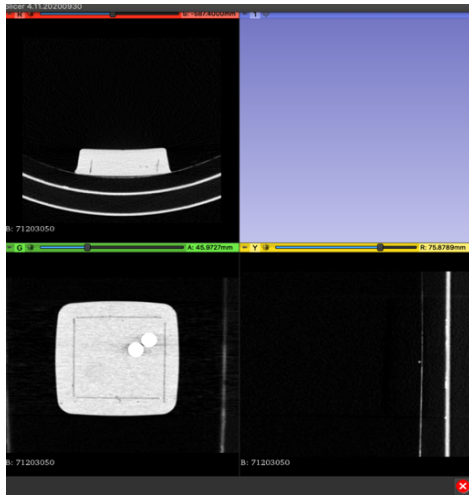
CT scan DICOM images opened with 3D Slicer. The squared mold is on the left while the spherical mold is on the right.
